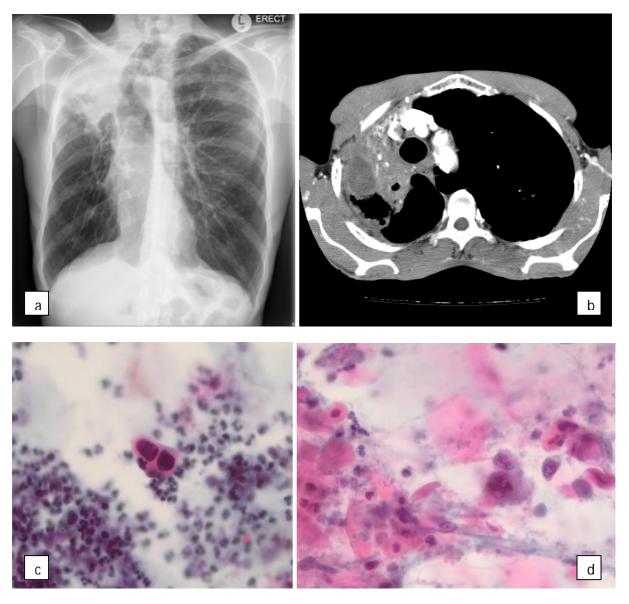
Spiculated mass of the right upper lobe with extension to the anterior thoracic lung cage and hilar involvement on chest X-ray (a) and CT (b). Sputum - malignant. Extremely hyperchromatic nuclei with keratinised cytoplasm (c).
